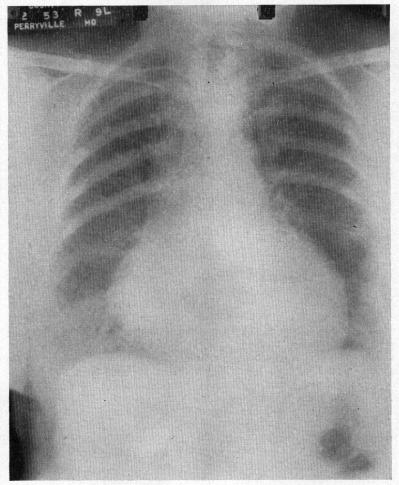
Chest x-ray performed 10 days before death reveals marked enlargement of the cardiac silhouette to both the right and the left. The enlargement was due entirely to a massive hemopericardium.
